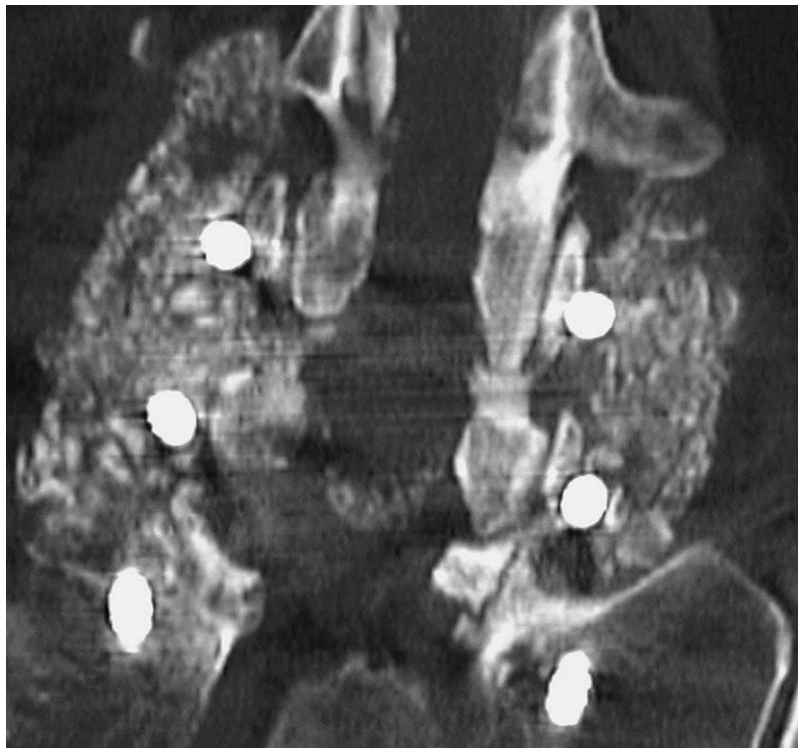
This coronal two-dimensional computed tomographic study obtained 6 months postoperatively revealed near continuous incorporation of the posterolateral fusion mass placed at the time of laminectomy and instrumented fusion from L4–S1. The graft included a 50:50 mix of autogenous laminectomy bone and B-TCP (Vitoss).
